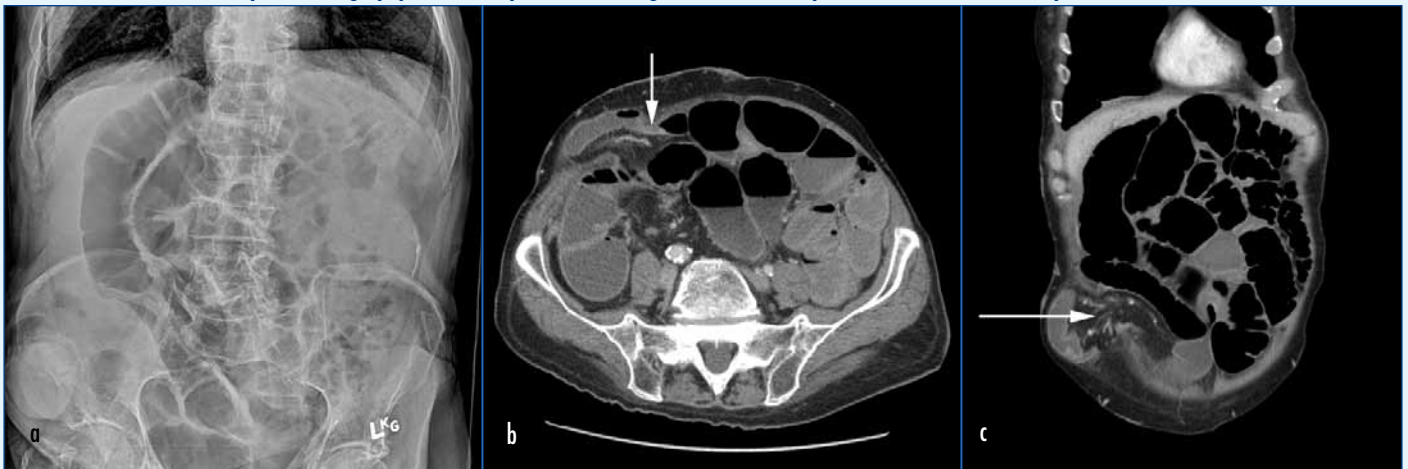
Small bowel obstruction in patient with multiple adhesions, post previous surgery. Multiple dilated loops of small bowel on (a) abdominal X-ray and (b) axial and (c) coronal computed tomography. Transition point is in the right iliac fossa and para-stomal hernia with loop of small bowel.
